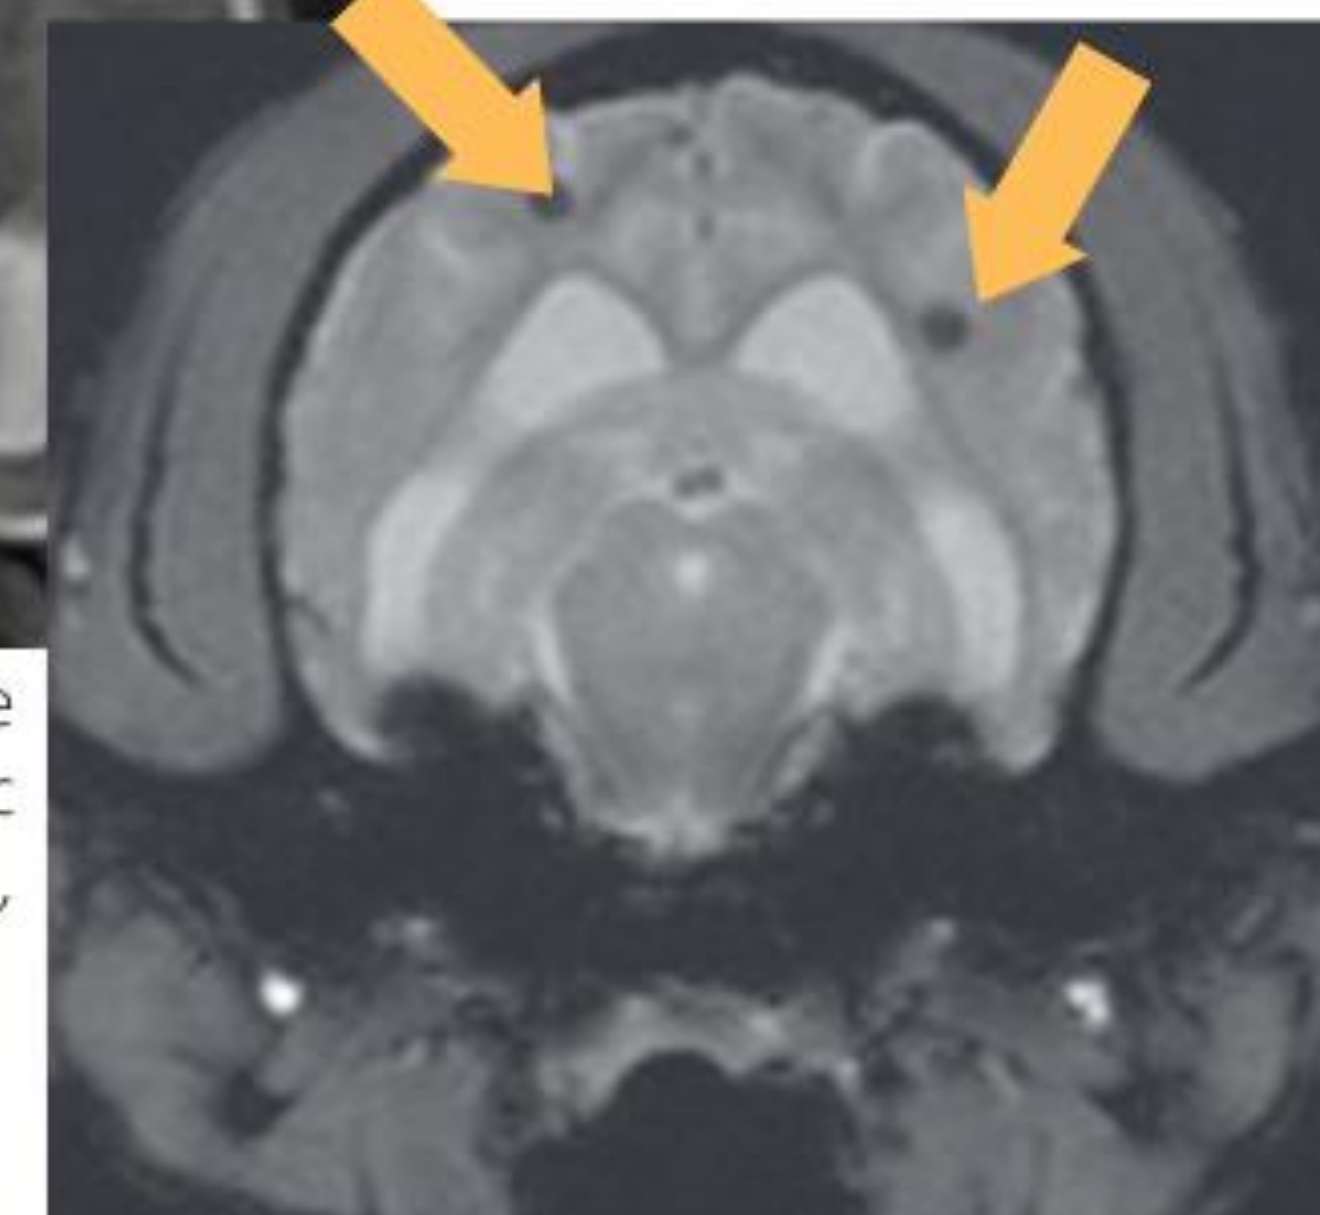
MRI where two hypointense dots can be seen in the encephalon, compatible with microhaemorrhages (Kerwin *et al.*, 2017)
